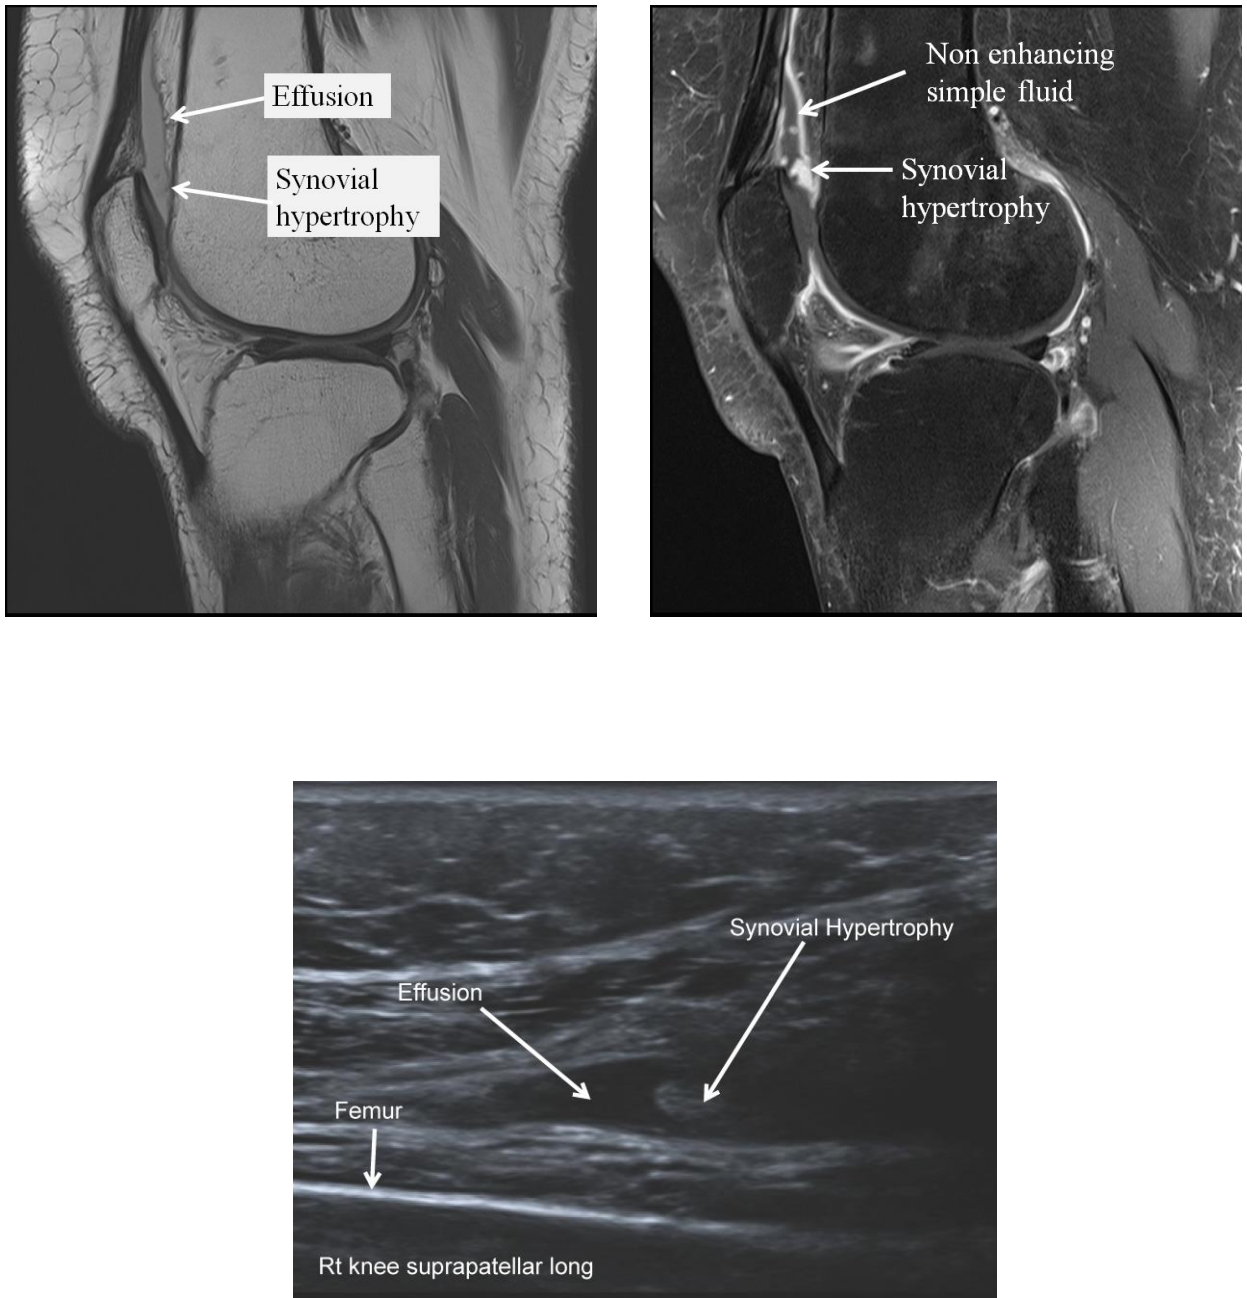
Sagittal fat-suppressed proton density (a), post-intravenous contrast sagittal fat-suppressed T1(b) MRIs and transverse ultrasound image (c) demonstrating synovial hypertrophy and effusion in the suprapatellar bursa of a knee in which there was moderate osteoarthritis in the medial femorotibial compartment.
